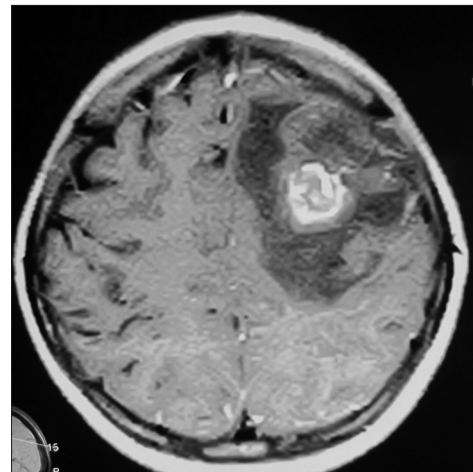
MRI (axial view) scan showing a thick ring-enhancing lesion seen in the left high parietal region with perifocal edema with mass effect
